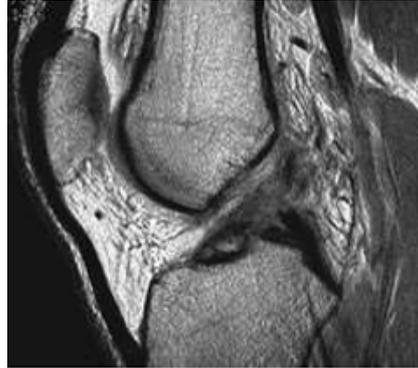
MRI scan documenting midsubstance rupture of the anterior cruciate ligament.
